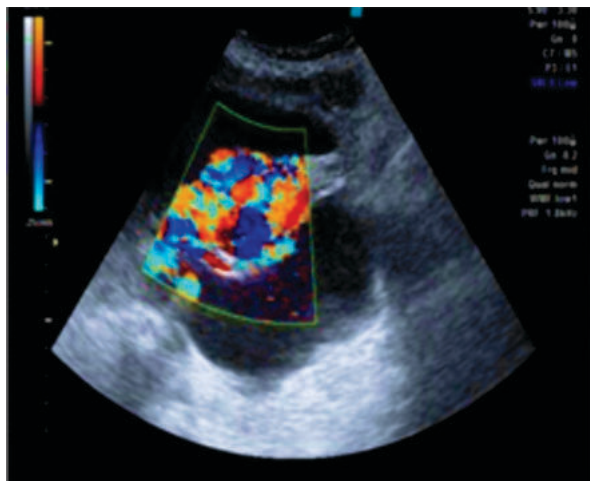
Doppler Showing Blood Draining Into The Cystic Spaces
